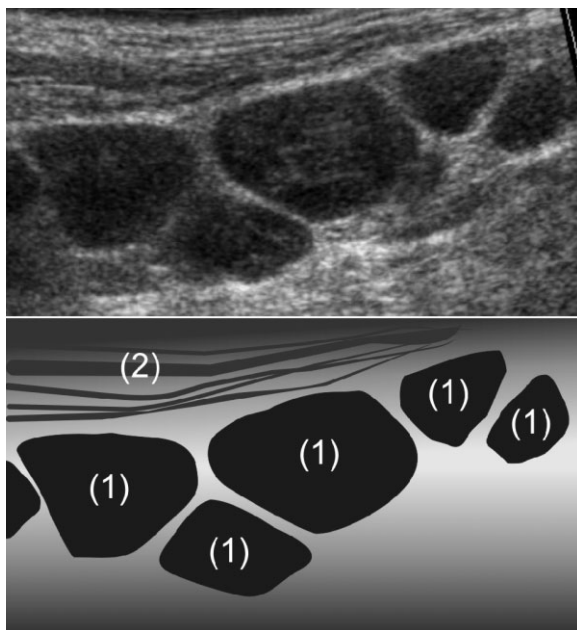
An ultrasound image and a scheme of multiple cervical lymph nodes modeling on each other and assuming geometrical shapes (1) in a 57-year-old male with a small lymphocytic lymphoma. (2) – sterno-cleido-mastoid muscle.
